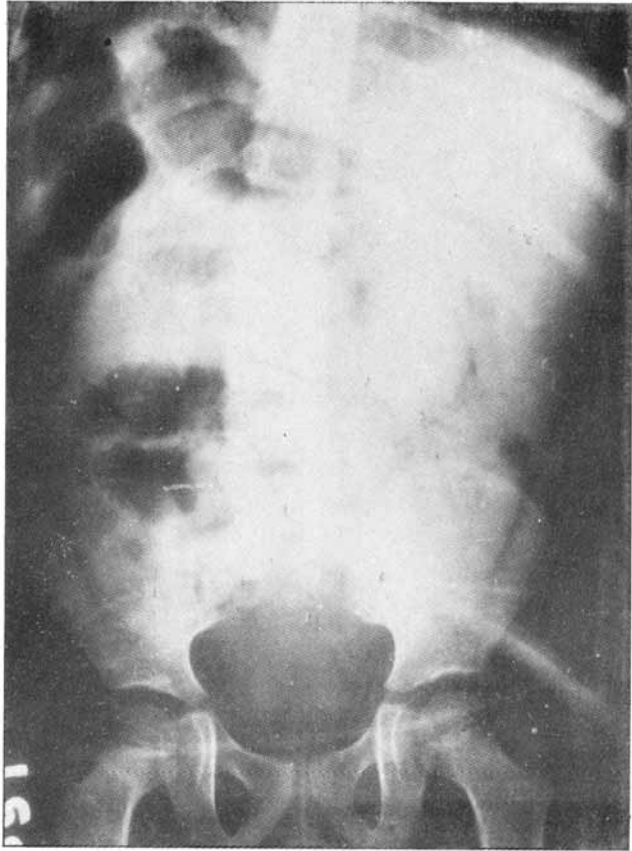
X-Ray showing absence of the spine below S1.
